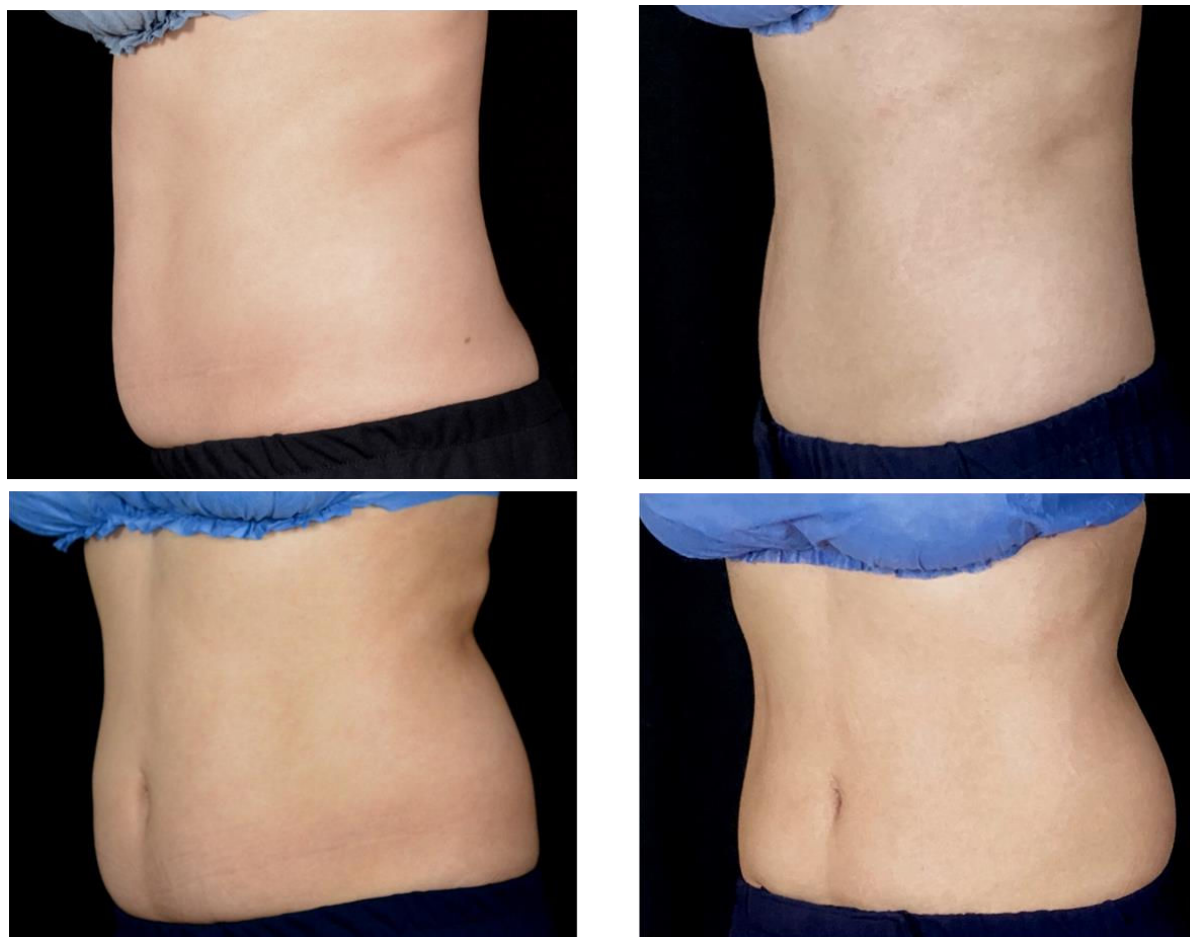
Before (left) and after (right) photograph of patient No. 9 (see Figure 1C and 1D for an MRI image from the same patient) with evident abdominal body shape aesthetic improvement.
